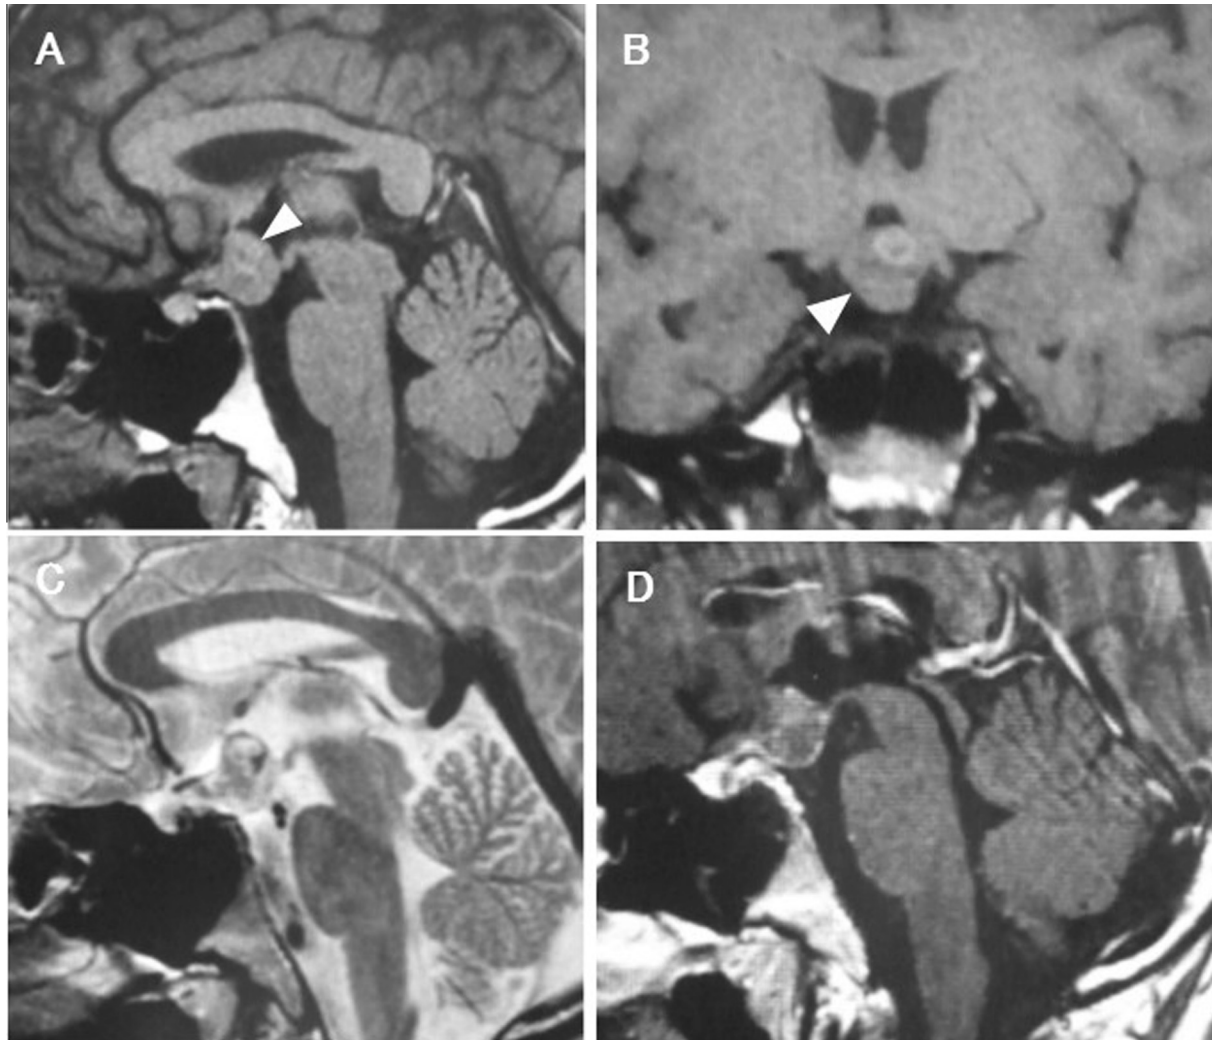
(a, b; sagittal, coronal) Initial T1-weighted MRI in 2006 revealed a tumor in the suprasellar region (arrowhead), (c) Sagittal T2-weighted MRI showing a mixed intensity lesion, (d) on sagittal T1-weighted contrast enhanced MRI the tumor slightly enhanced with gadolinium.
